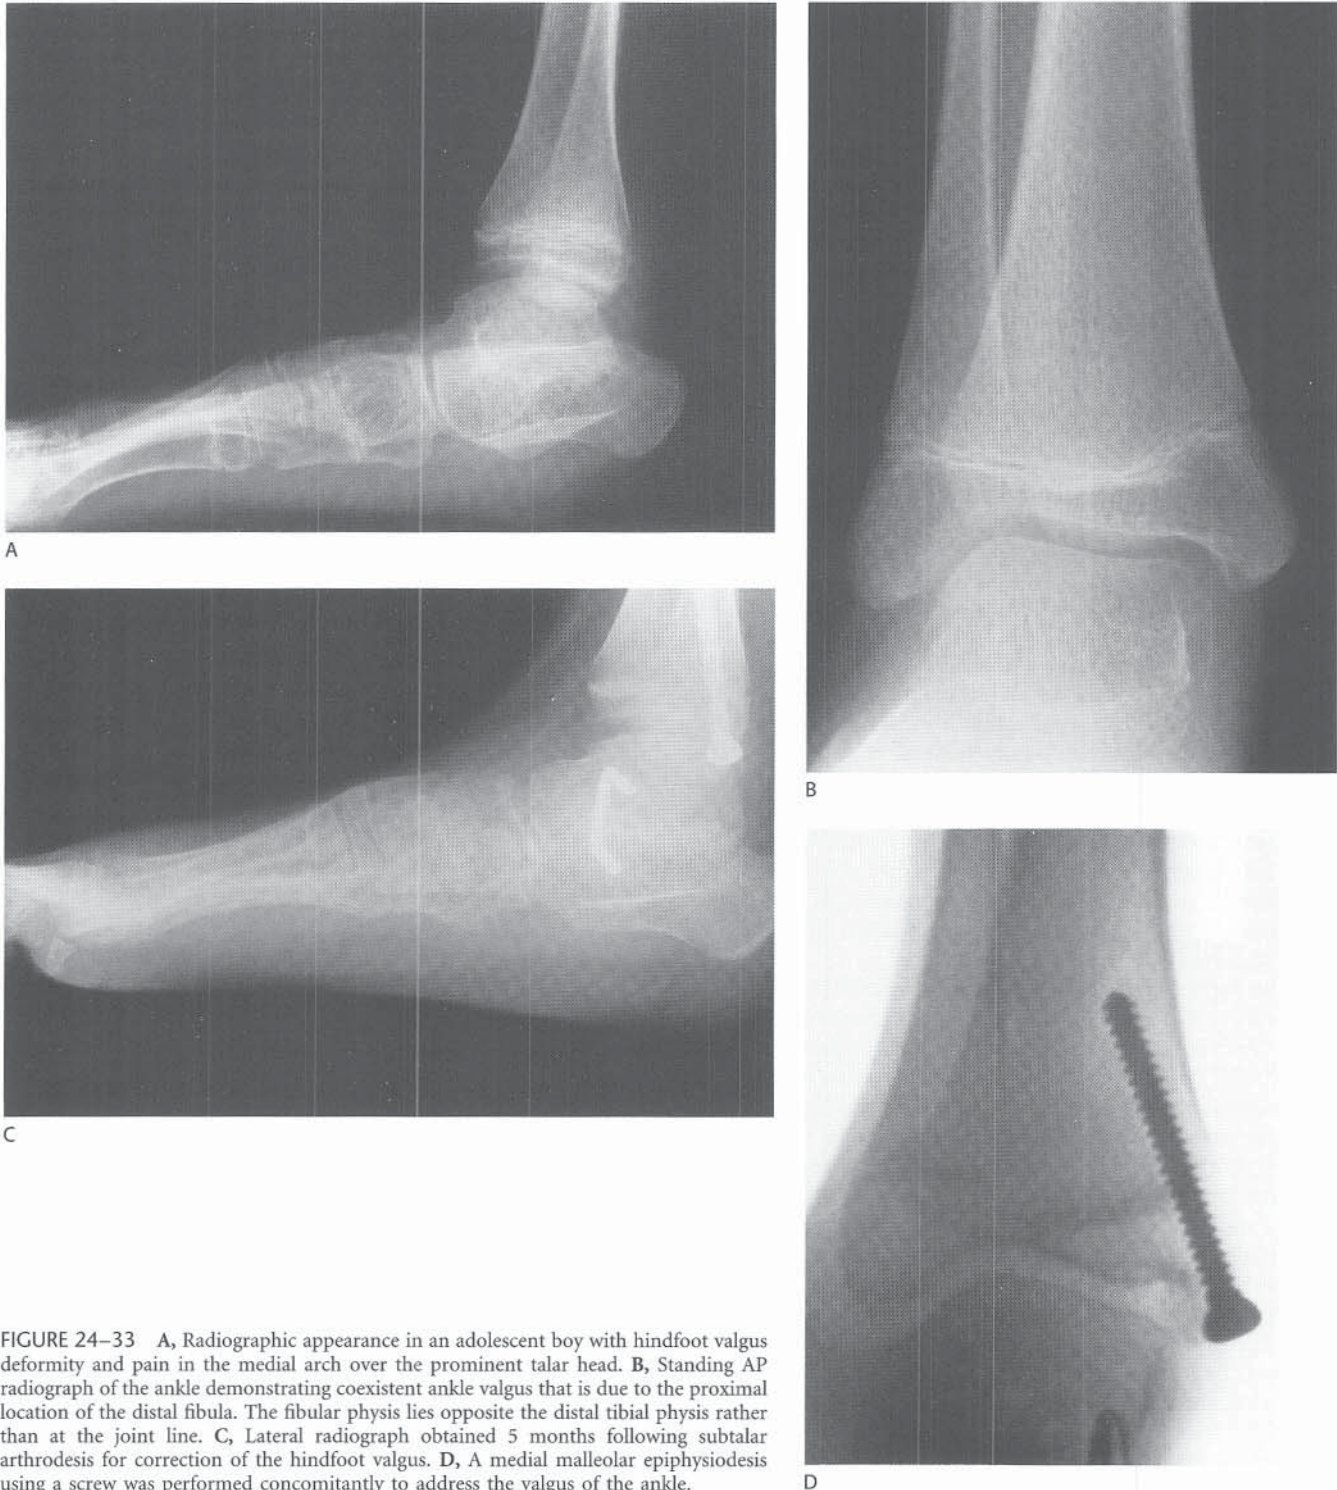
A, Radiographic appearance in an adolescent boy with hindfoot valgus deformity and pain in the medial arch over the prominent talar head. B, Standing AP radiograph of the ankle demonstrating coexistent ankle valgus that is due to the proximal location of the distal fibula. The fibular physis lies opposite the distal tibial physis rather than at the joint line. C, Lateral radiograph obtained 5 months following subtalar arthrodesis for correction of the hindfoot valgus. D, A medial malleolar epiphysiodesis using a screw was performed concomitantly to address the valgus of the ankle.
